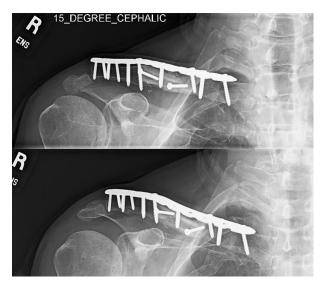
Radiographs (same patient shown in Fig. 2) at 1 year after vascularized fibula graft transplantation, showing stable fixation and bony healing.
